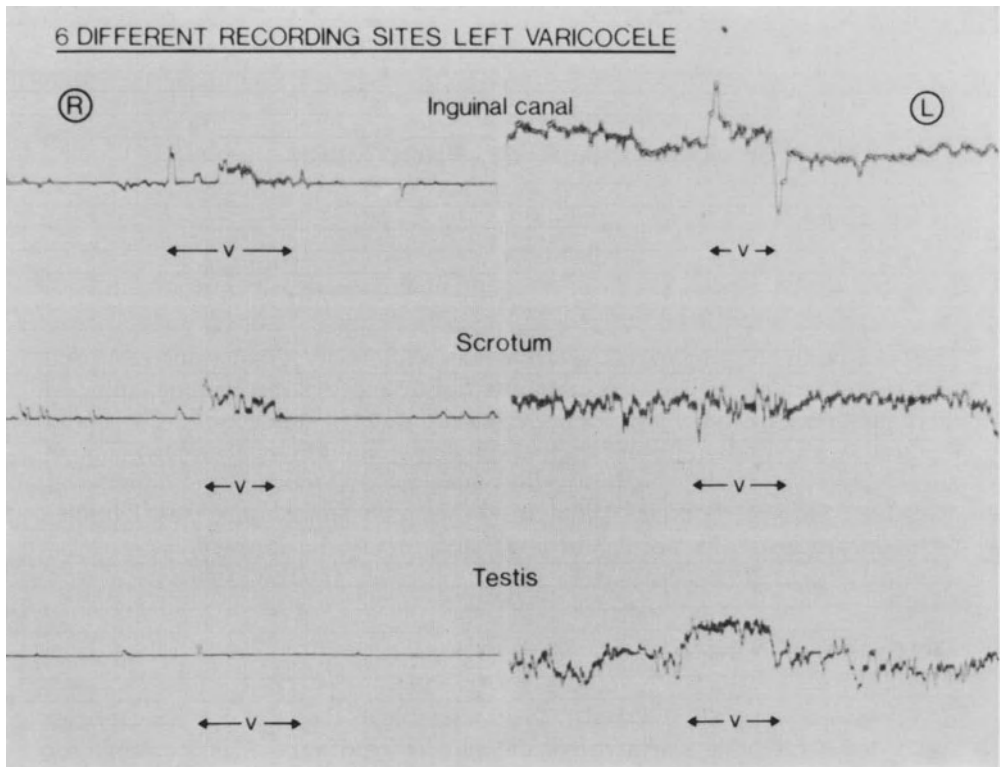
Wave-forms recorded by a directional Doppler velocimeter during quiet respiration while standing and also during Valsalva's manoeuvre (V) over the right and left spermatic cords at three levels
